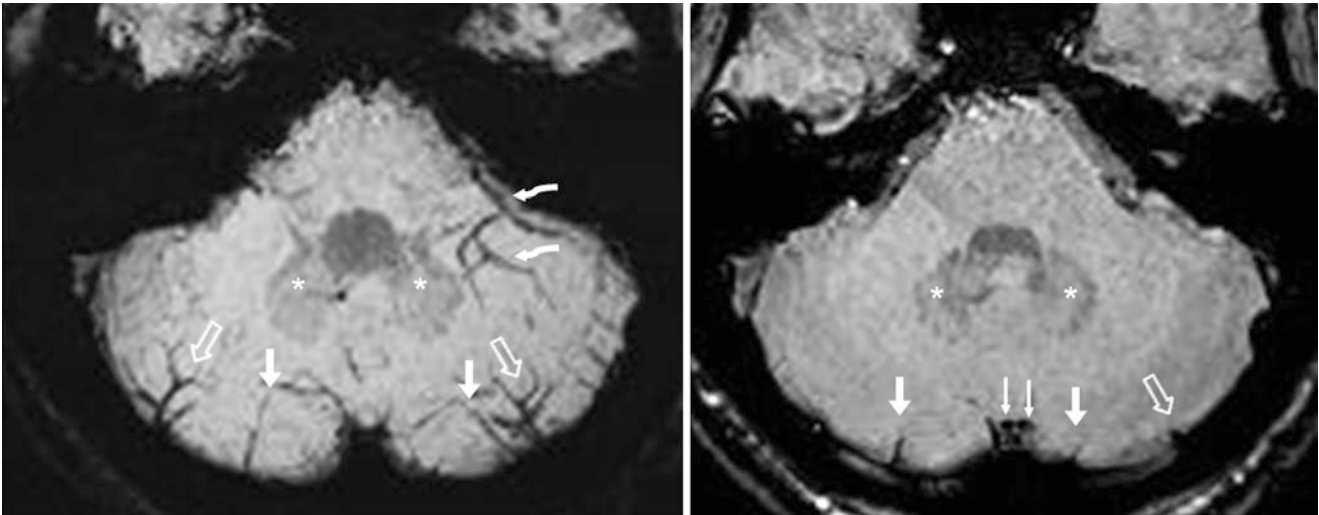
This 17-year-old had a 3 T MRI that implemented SWI at thicknesses of 12 mm (*left*) and 2 mm (*right*). Note that the paired IVVs (*thin arrows*) are difficult to distinguish on the thicker SWI. Also, note the LICVs (*open arrows*), and MICVs (*short arrows*). The left PVs
